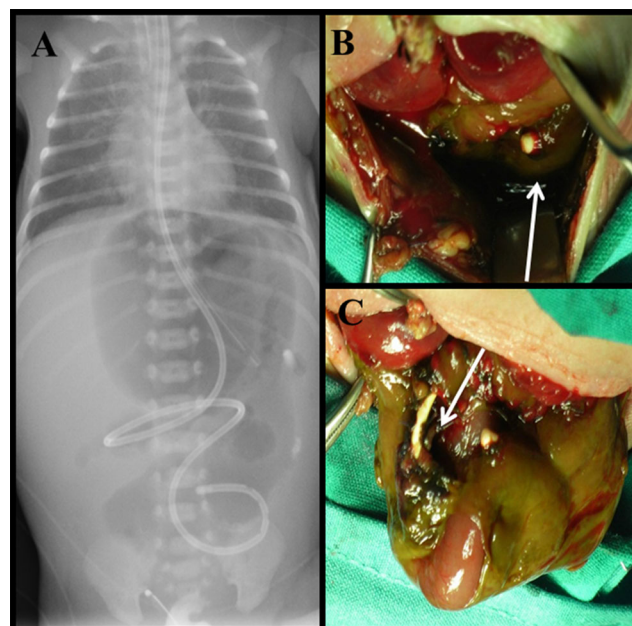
X-ray of the abdomen demonstrating pneumoperitoneum a. Exteriorization of transanastomotic tube through intestinal perforation (white arrows) and intense diffuse peritonitis b, c
